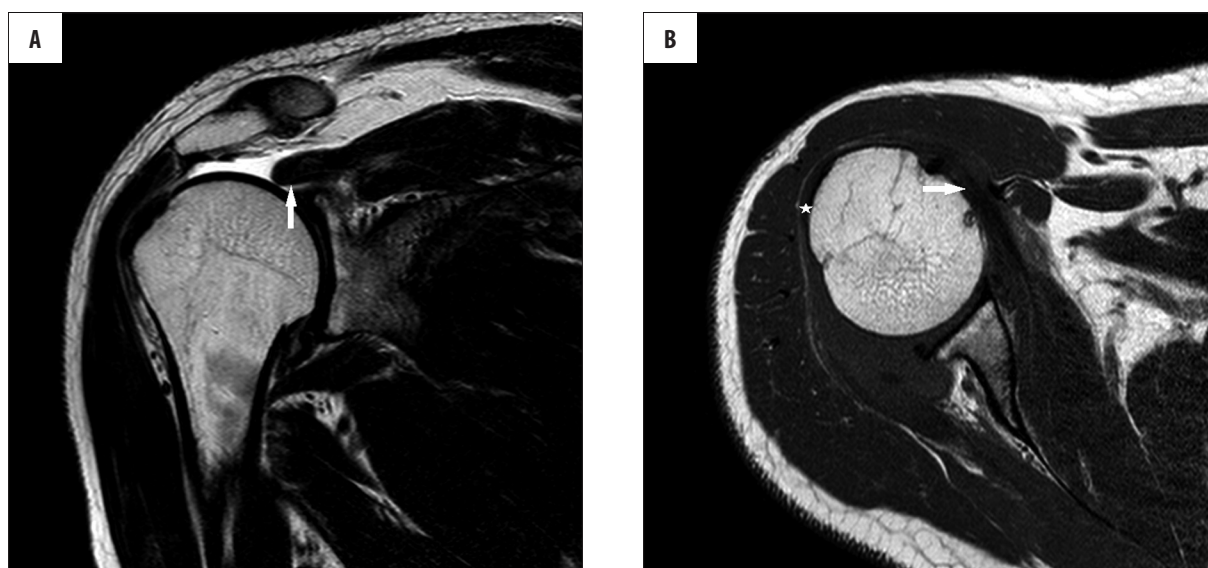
Shoulder MRI. (A) T2-weighted image, frontal plane. Complete supraspinatus tear (arrow) with muscle partial retraction. Increased volume of subacromial-subdeltoid bursa fluid. (B) T1-weighted image, transverse plane. Partial tear (star) of subscapularis (arrow) and infraspinatus tendons (star).
